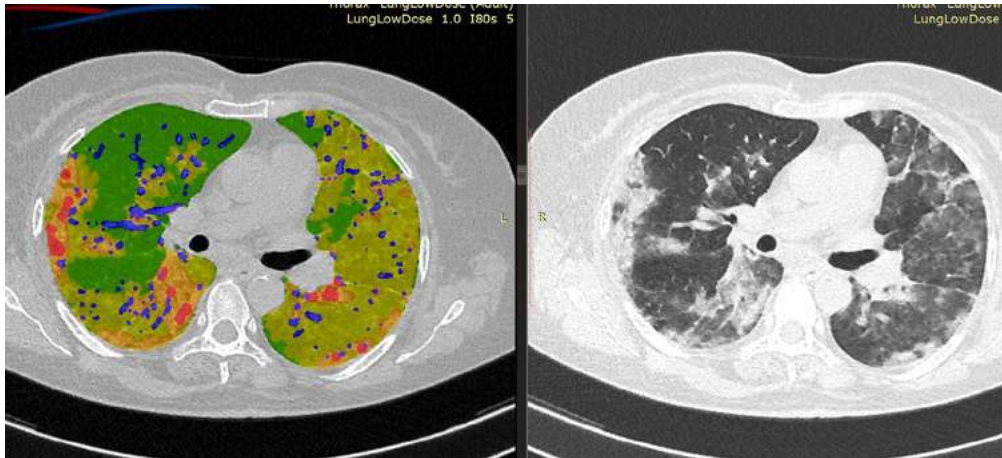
Follow-up of COVID-19 progression with CT. Right side — processed CT image on the day of admission. The total volume of GGO/consolidations in the lungs — 7.2%. Left side — processed CT image after 5 days. The total volume of GGO/consolidations in the lungs — 26%, indicating the progression of the disease.
